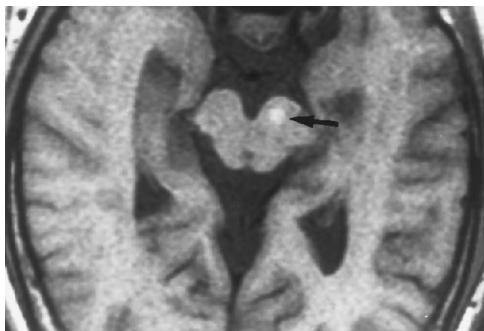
Fascicular lesion in a 40-year-old human immunodeficiency virus-positive man. Axial T1-weighted image demonstrates a small hyperintense lesion (*arrow*) that was present on both the T1-weighted images and the T2-weighted images. This appearance is consistent with a hemorrhagic lesion of unclear cause in this patient.
